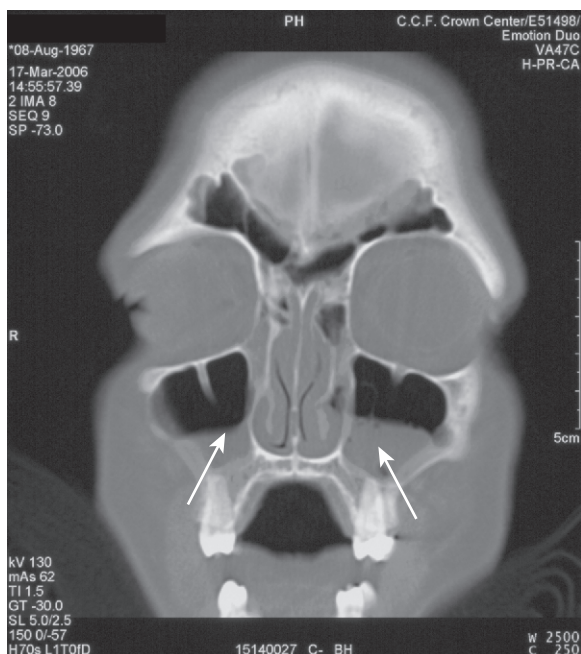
Computed tomography scan showing acute sinusitis. Note the fluid levels in the maxillary sinuses (arrows). (From *Cleveland Clinic: Current Clinical Medicine*, 2nd ed. Philadelphia, Saunders, 2010.)
